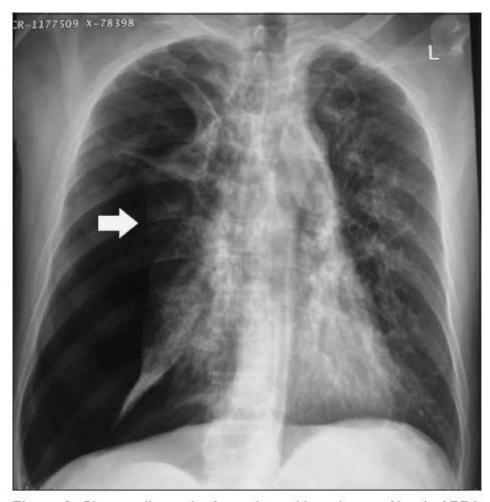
Chest radiograph of a patient with end-stage fibrotic ABPA who presented with a right-sided spontaneous pneumothorax (arrow)
